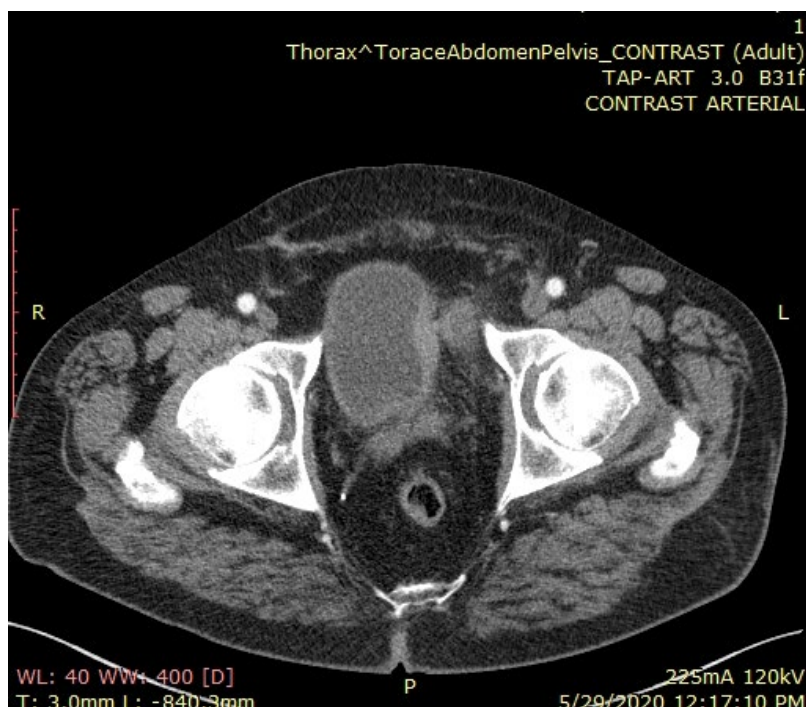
CT scan after neoadjuvant chemotherapy
